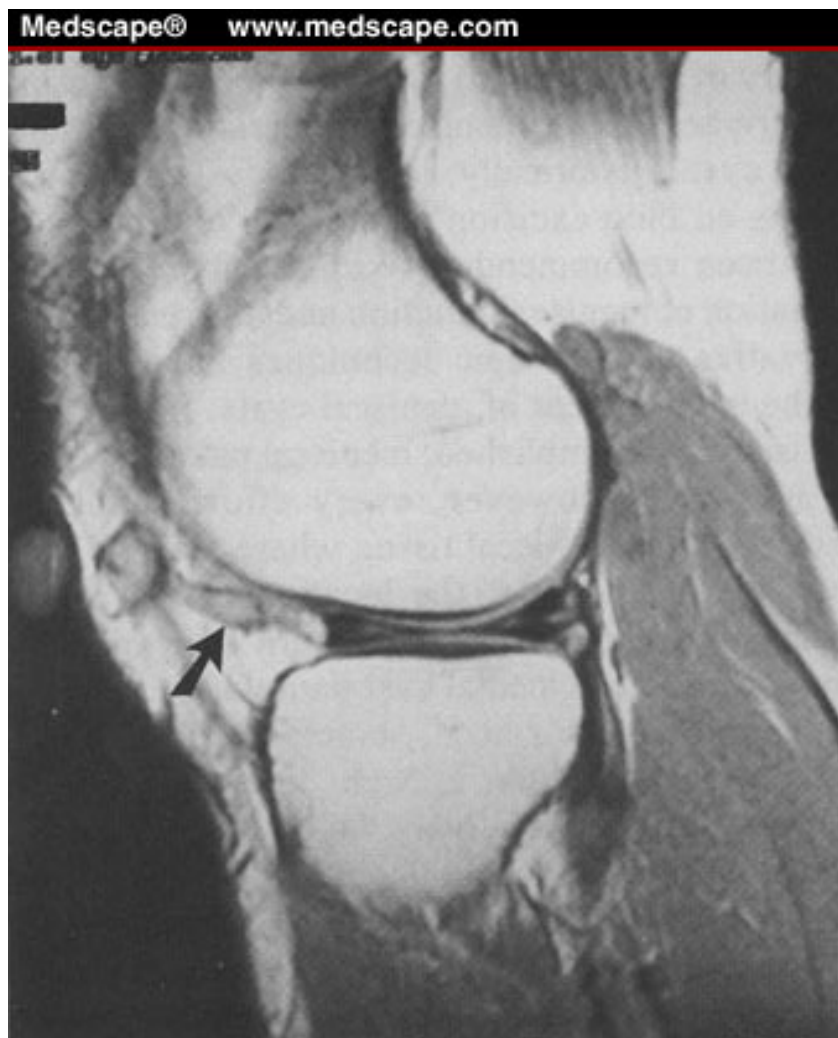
MRI finding of complex serpiginous tract (arrow) associated with lateral meniscal tear, with cyst presenting adjacent to the patellar tendon. (Reprinted with permission.)
